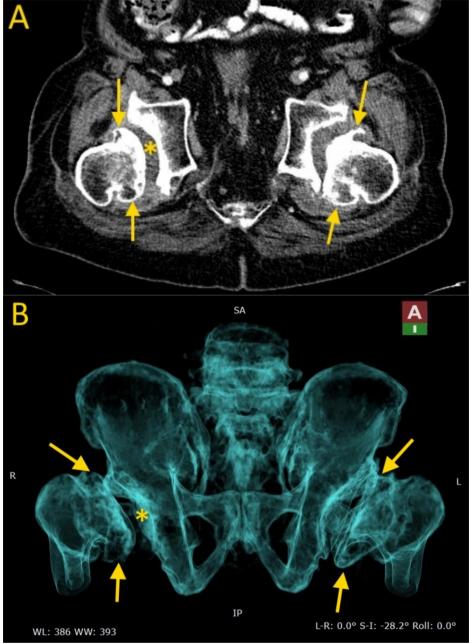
The CT scan detects deformation of the femur head (yellow arrow) and shallow hip socket (yellow asterisk): A – image with axial reconstruction, B – image with 3D reconstruction.
